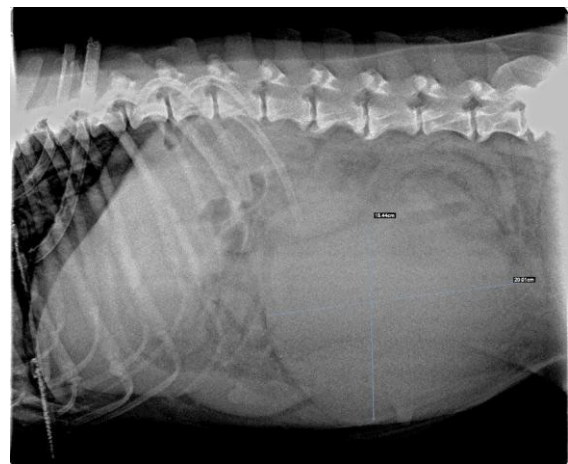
Lateral abdominal radiograph showing a large mass (15 cm x 20 cm) in the ventrocaudal abdomen.
